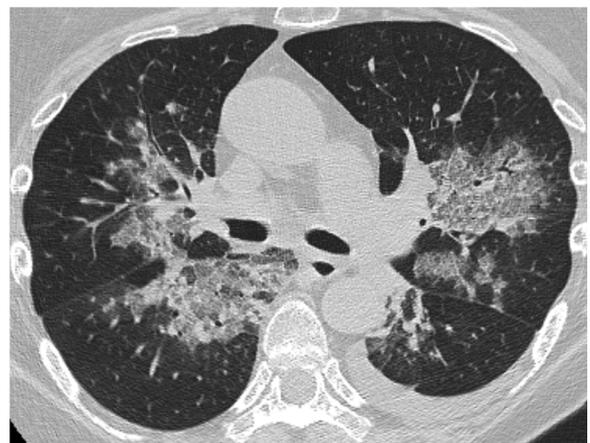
Organizing pneumonia in a severely dyspnoeic 64-yr-old woman receiving everolimus for stage IV breast cancer. HRCT shows bilateral ground-glass opacities and consolidation with peribronchovascular distribution, defining a bronchocentric pattern of organizing pneumonia. The patient experienced rapid clinical improvement after withdrawal of everolimus, with subsequent resolution of HRCT findings (not shown).
